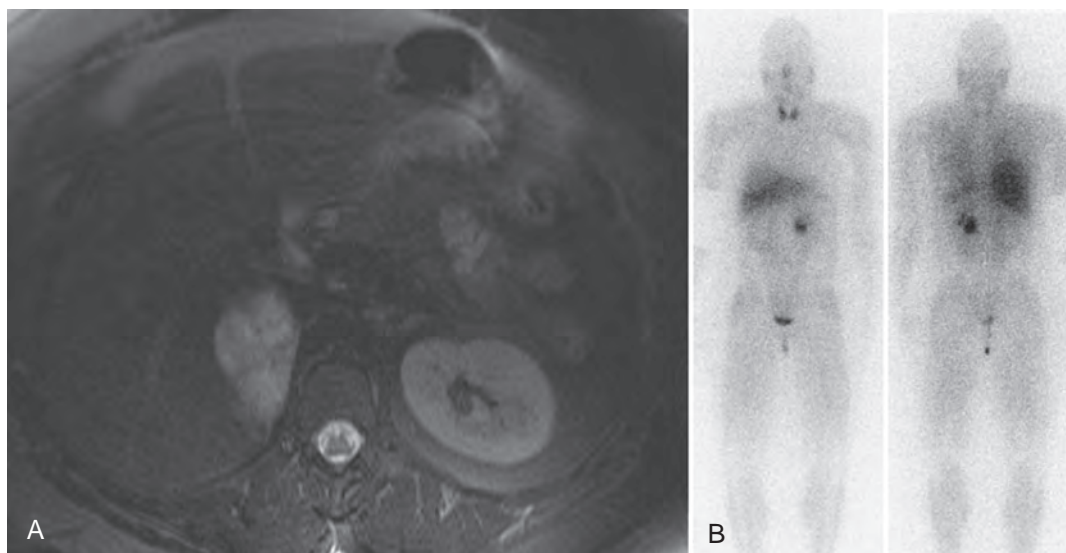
Imaging of pheochromocytoma. A, Axial T2-weighted magnetic resonance image of a right adrenal mass that proved to be pheochromocytoma. B, Metaiodobenzylguanidine (MIBG) scan of a different patient with a localized left pheochromocytoma. Normal uptake can be seen in the liver, salivary glands, thyroid, and bladder. It is important to note that fluorodeoxyglucose positron emission tomography appears to be superior to the MIBG scan with a notable exception of patients with known multiple endocrine neoplasia type 2 (A, Courtesy Dr. Rosaleen Parsons, Fox Chase Cancer Center, Philadelphia; B, courtesy Dr. Michael Yu, Fox Chase Cancer Center, Philadelphia.)
